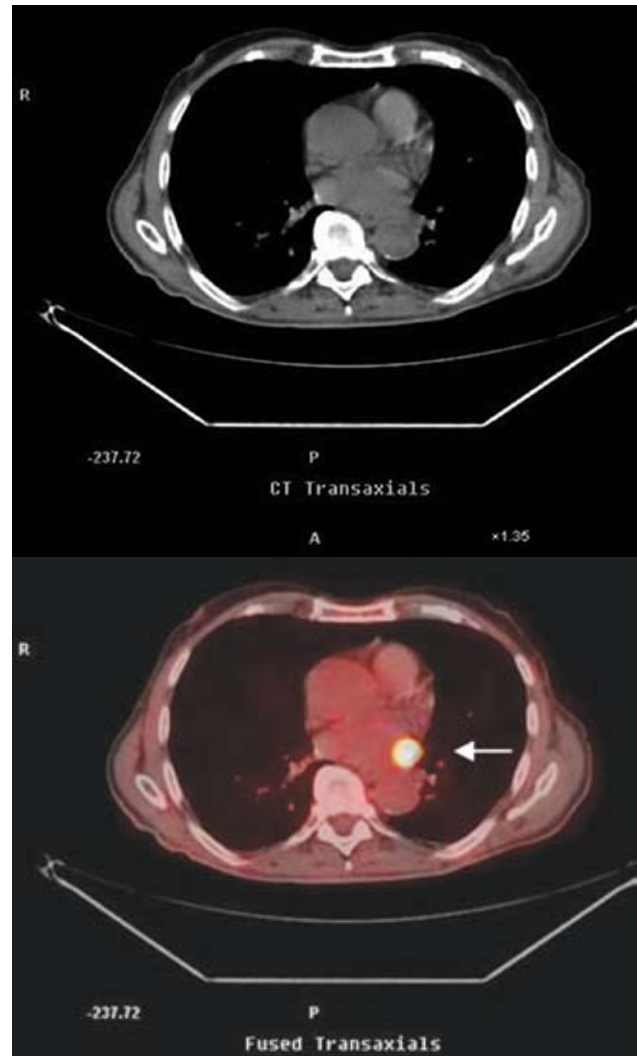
PET/CT: Metastasis in the left atrium from melanoma.
